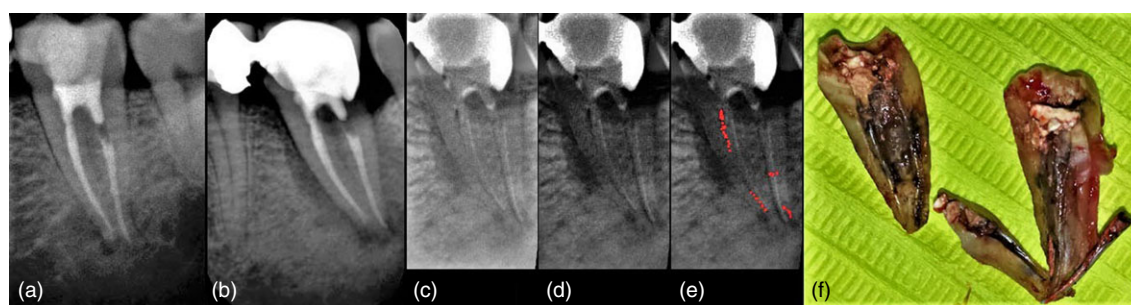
(a) Post-operative radiograph. (b) After 6 years: radiolucency towards the furcation area of the roots, the mesial and apical area. No fracture line is visible. (c) Result of digital subtraction of b from a: a dark oblique line in the body of the root at its mesial part is visible and two smaller in the distal root. (d) DSI processed using CET. (e) Image d processed using PCT. (f) VRF was confirmed after the extraction of the tooth.
